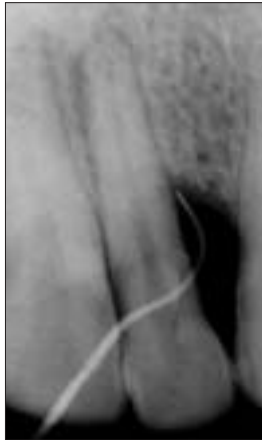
Outcome classified as "functional." Pre-operative radiograph of a mandibular lateral incisor with apical periodontitis and a palatal developmental groove associated with an extensive bone loss. Prognosis of this condition is recognized as hopeless; however, the patient decided to proceed with treatment in an attempt to retain the tooth in function as long as possible.
